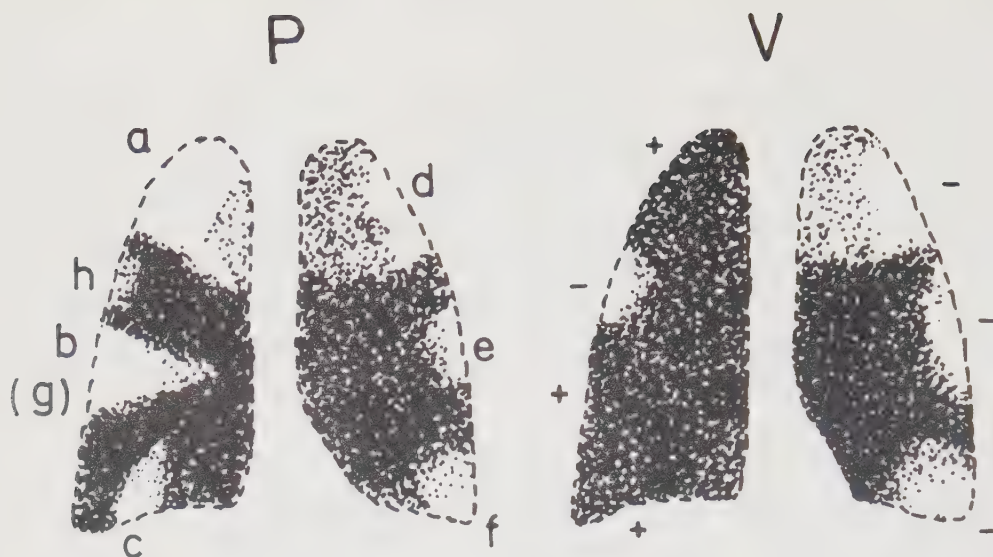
System for coding of scintigraphic abnormalities.
